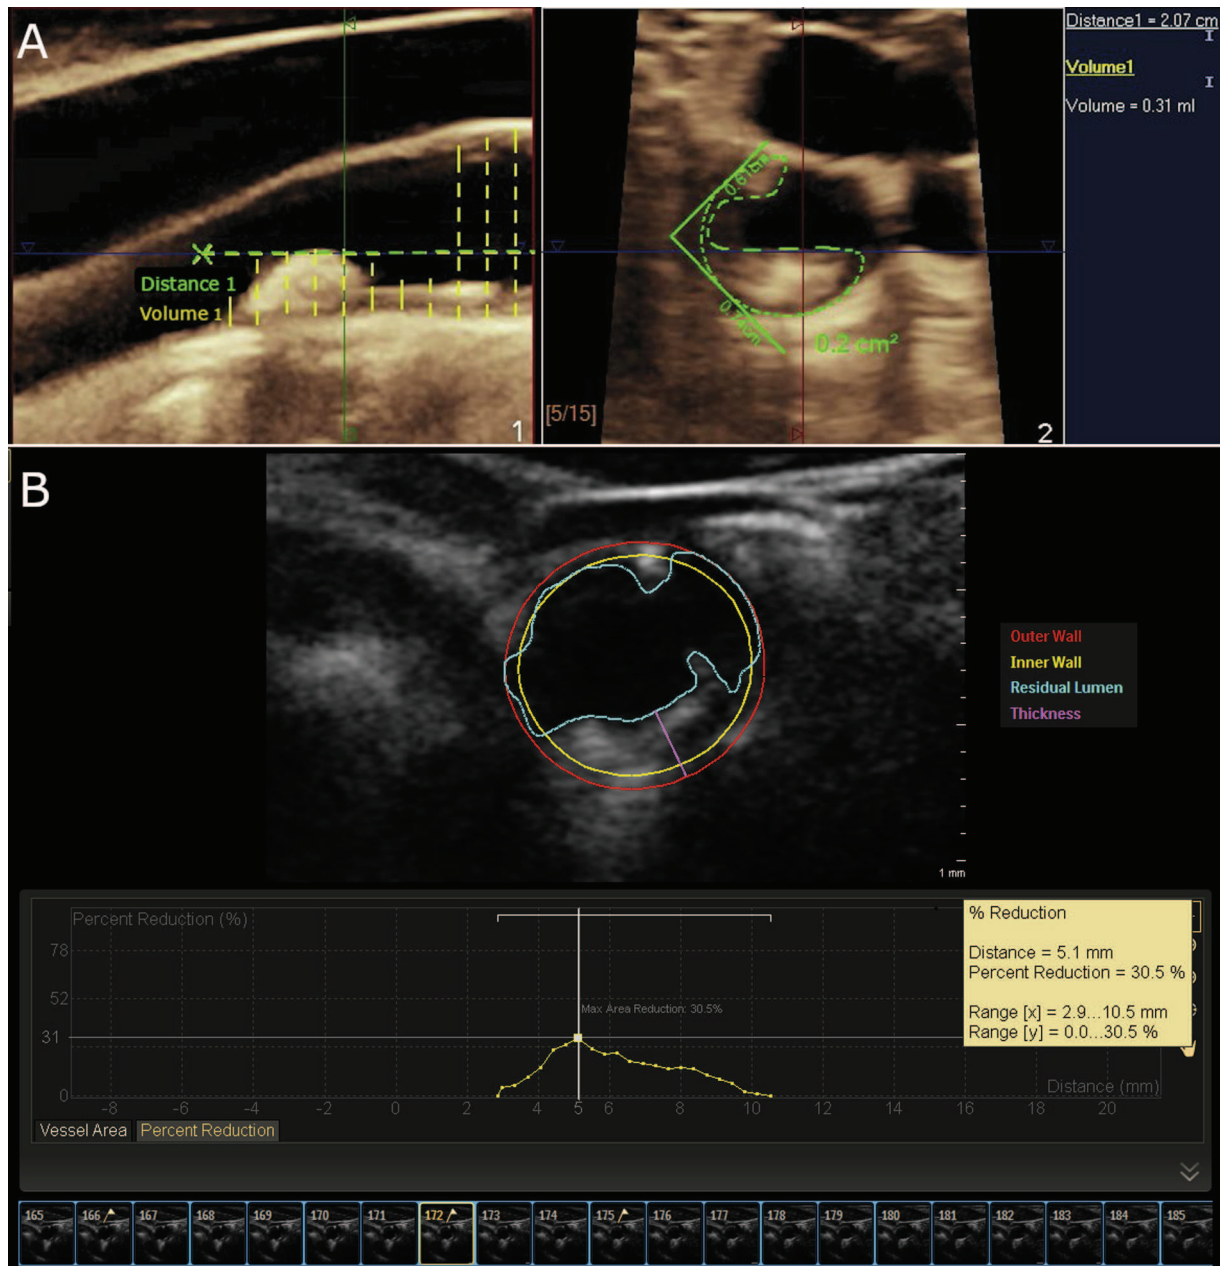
A and B. 3D plaque volume analysis. Panel A: Carotid arterial plaque, acquired by 3D ultrasound and quantified by the stacked contour method. The arterial plaque is identified in the 3D volume dataset using multi-planar reconstruction (MPR) mode. The length of the plaque is identified, and the stacked contour method allows for area calculation of orthogonal views of the plaque along a series of ‘slices.’ The slices are integrated by the software to provide a volume measurement. Panel B: Carotid arterial plaque, acquired by 3D ultrasound and quantified using specialized semi-automated software (Philips Healthcare VPQ). The acquisition begins with a short-axis view of the bifurcation in a series of image frames (similar to a video segment). The start (first frame) and end (last frame) of the plaque are outlined in short-axis using an ellipse and represent “no plaque”, then the key frame in the center of the plaque is outlined to represent “plaque”. The total plaque volume, maximum thickness, and % lumen reduction are automatically calculated. Reference frames can be manually modified as necessary. The software places the outer wall at the medial-adventitial layer (*red circle*). Following input of the estimated size of the medial thickness (typically 0.5 mm), the software creates the yellow circle representing the intimal-medial thickness 0.5 mm in from the outer wall. Using a form of edge detection, the software traces the residual lumen as echogenic areas extending beyond the inner wall (*cyan line*). The area between the residual lumen and the inner wall (intimal-medial plane) represents plaque. The software models these parameters for each slice derived from the three-dimensional reconstruction, each of which can be manually reviewed and adjusted. Automated registration of this modeling and slices through the full-volume acquisition provide plaque volume and % lumen reduction.
